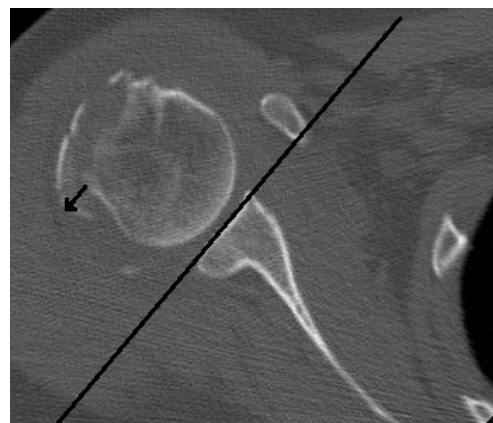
= Anterior/Posterior displacement calculated in the axial plane of computed tomography scans. The plane of displacement was defined parallel to a tangent drawn along the surface of the glenoid. Anterior/Posterior displacement was then directly measured on the slice demonstrating the greatest fragment displacement, as shown.
